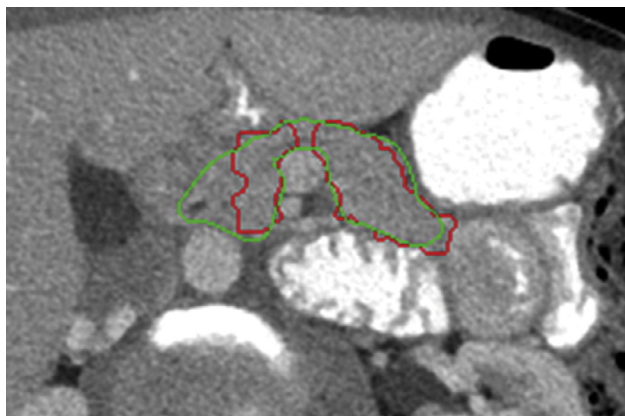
Automated pancreas segmentation (red) with manual tracing (green) of the pancreas in a 48-year-old woman. The pancreas is poorly delineated due to an absence of peripancreatic fat. There is relatively homogeneous intrapancreatic CT attenuation. DSC = 0.61. Standard Deviation of pancreatic attenuation = 17.5 HU. Average Attenuation of Pancreatic Neighborhood = 108.2 HU. (Color version of figure is available online.)
